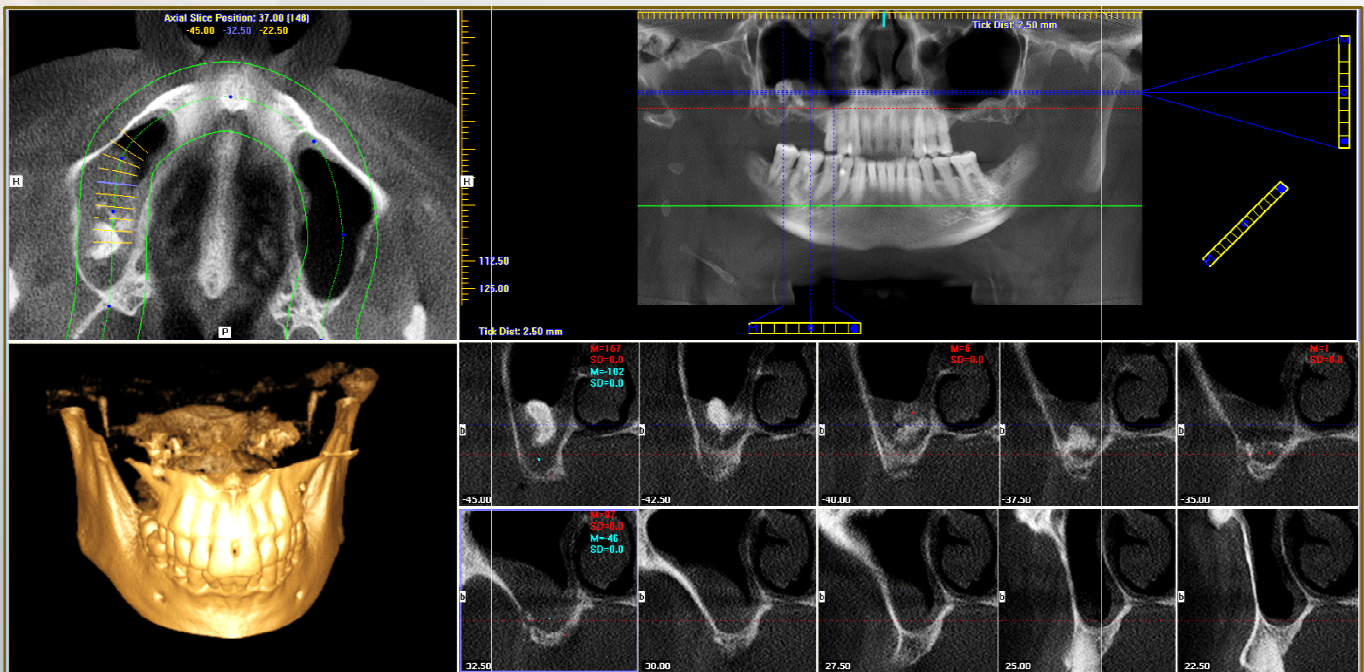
Six month CBCT demonstrating bone fill in the augmented area with evidence of residual graft material
